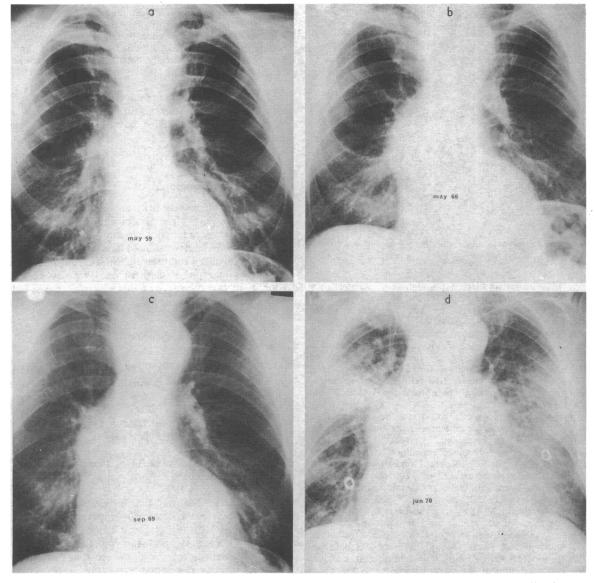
d—Sequence of chest radiographs from May 1959 to June 1970. Progressive enlargement of the heart and dilatation and elongation of the thoracic aorta are shown. The last radiograph is an antero-posterior projection using a mobile x-ray unit on the ward. The patient was by this time in intractable cardiac failure with pulmonary oedema.
